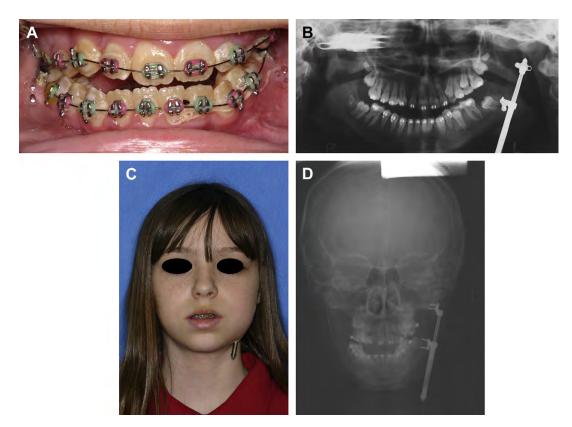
(A, B) Occlusion and panorex showing overcorrection. (C, D) Frontal view and posteroanterior cephalometric radiograph showing symmetry.
